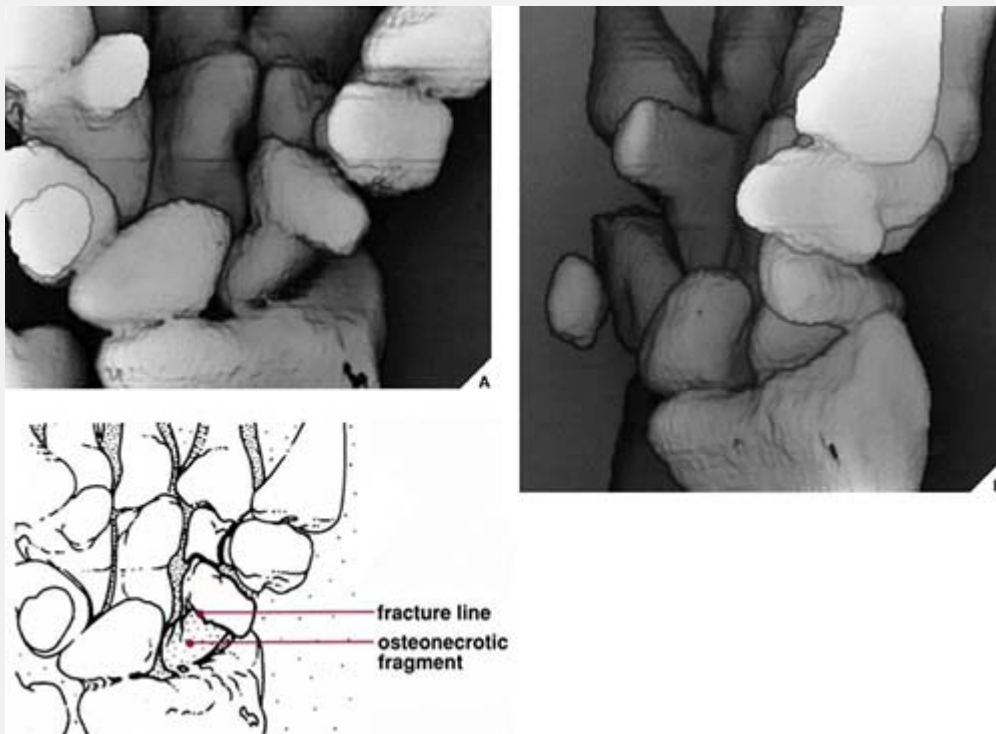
CT three-dimensional imaging. Anteroposterior (A) and oblique (B) three-dimensional CT reformation of the wrist demonstrates a fracture through the waist of the scaphoid bone, complicated by osteonecrosis of the proximal fragment.
